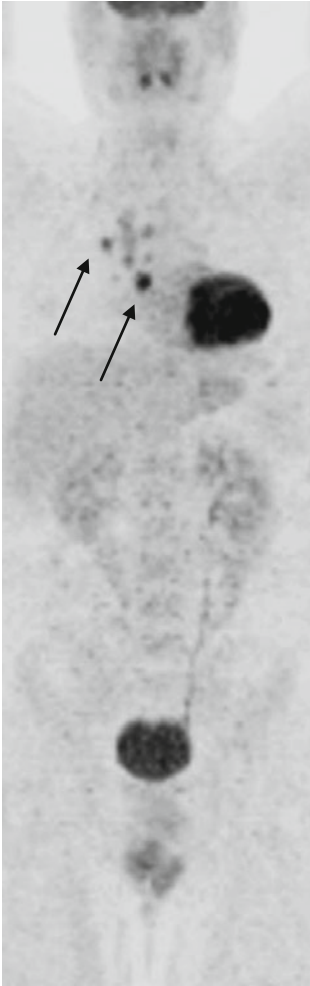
PET/CT after ABVD therapy. PET/CT assessment at that point showed increased 18-FDG uptake (SUV_{max} 13) in mediastinal lymph nodes and a lung nodule of 2 cm diameter in the right upper lobe (*arrows*). The findings were graded as score 5 according to the D5-PS and the patient had progressive disease according to CT findings
